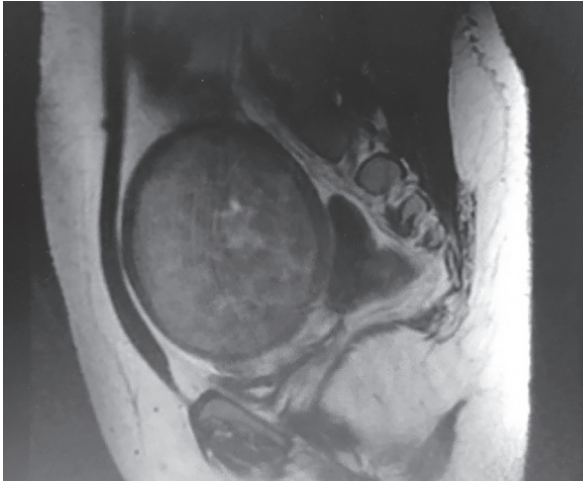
MRI image—abdomen
